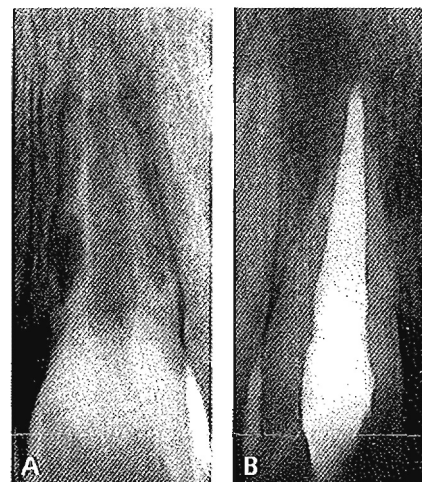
(A) Radiograph of incisor tooth with inflammatory root resorption. (B) Radiograph of incisor with replacement root resorption. There is loss of root structure, along with absence of a PDL space. (Images courtesy of Dr. Frederic Barnett.)
